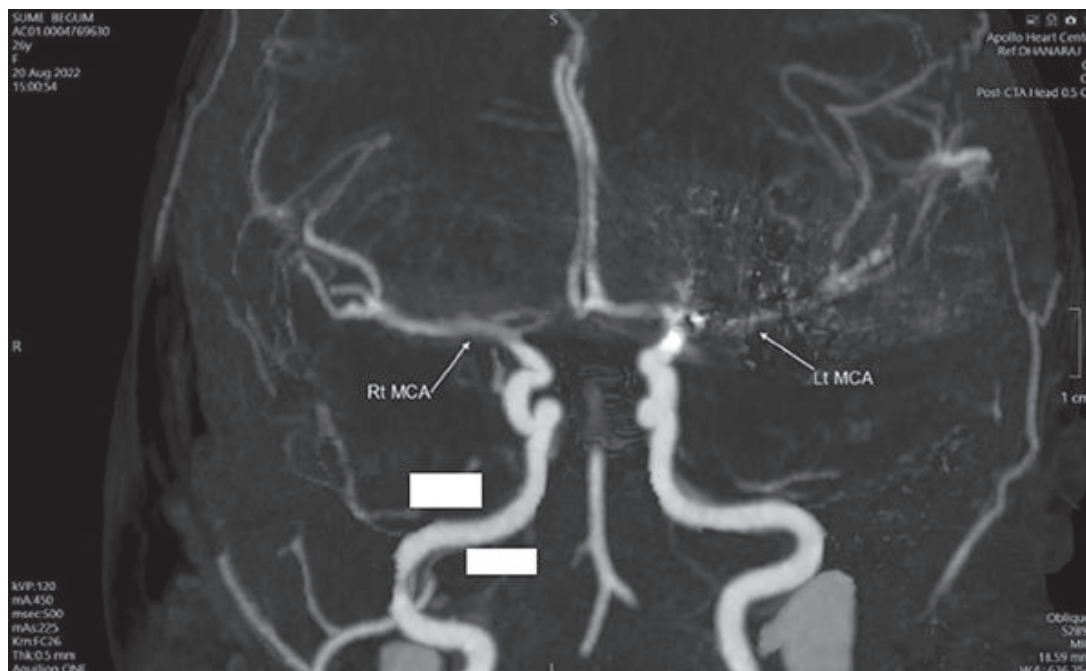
CT Imaging of 10 days after the interventional procedure of FD. No cerebral edema was seen in this CT image too.
